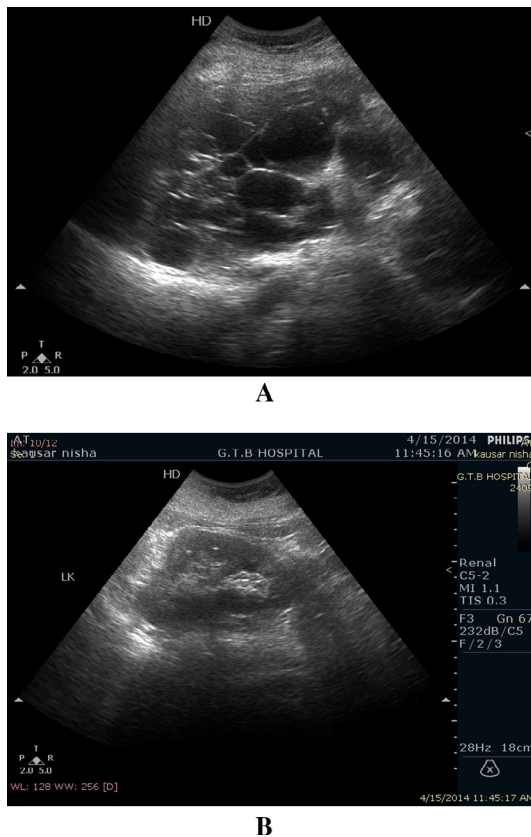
Ultrasound image showing: (A) An enlarged right kidney replaced with variably sized cysts. (B) Normal contralateral left kidney.
